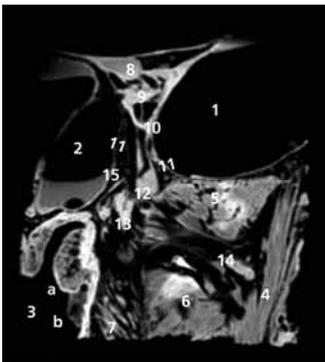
Coronal MR image of left PPF
